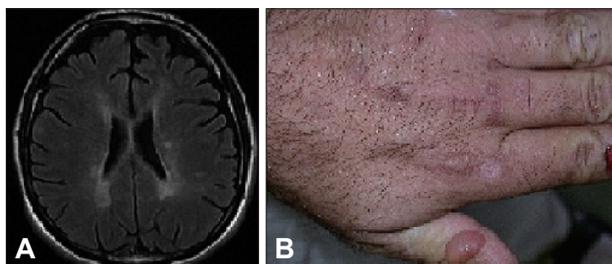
A: MRI showing several demyelinating lesions. B: Skin lesions on the back of the patient's hands.
